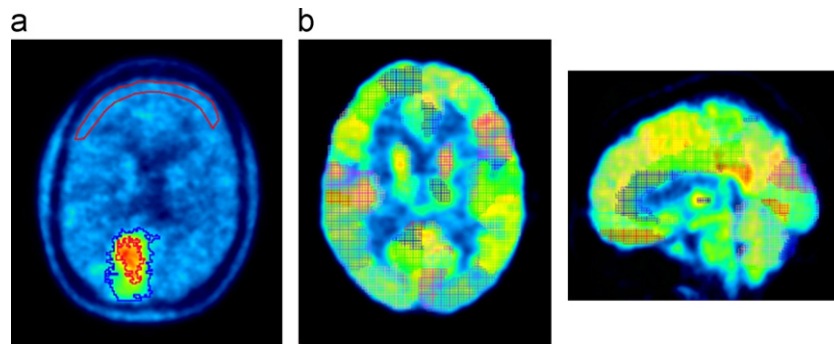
VOIs for analysis of FET (a) and FDG images (b).
